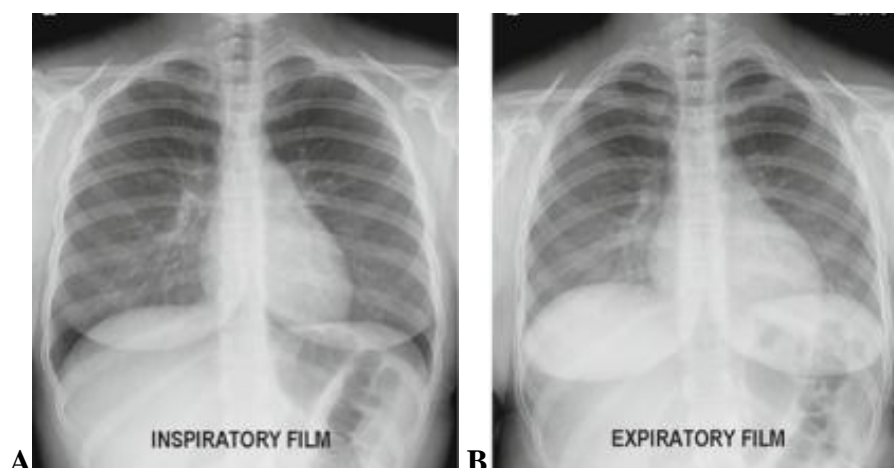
(A) Inspiratory and (B) expiratory the radiographs female here are those of inspiration and expiration. Note the difference in the size of the lungs and their apparent difference in densities
